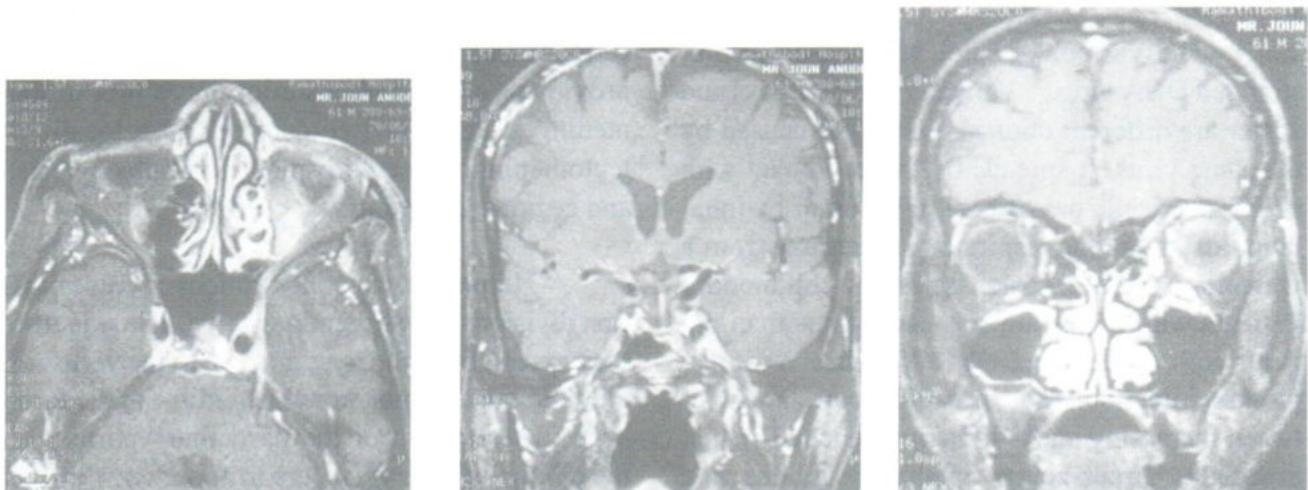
I.V. enhanced axial and coronal MRI of the orbits showed abnormally increased enhancement of the cisternal, intracavernous portions of the trigeminal nerve and the V1 branch of left side.
